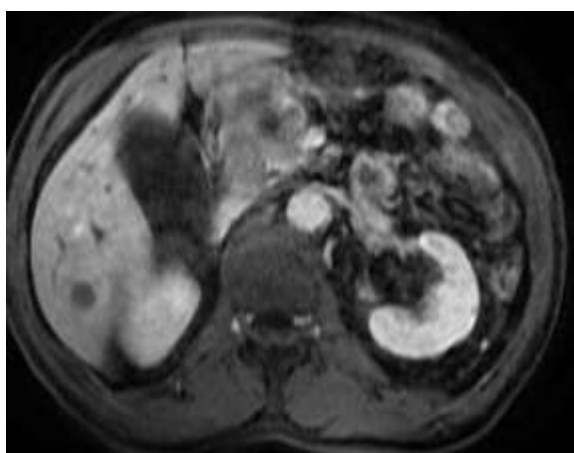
CE MRI of upper abdomen: Axial plane: Pancreas head and neck neoplasm with with local infiltration of adjacent blood vessel and infiltration in duodenum, distance metastases (liver)
